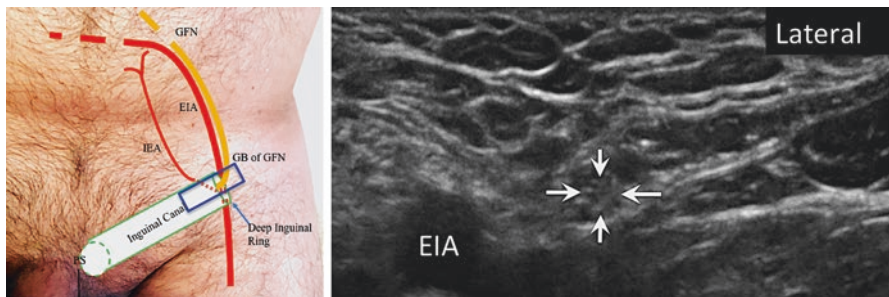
Position of ultrasound probe and the corresponding sonography revealing the genital branch of the genitofemoral nerve (arrows). EIA external iliac artery. (Reprinted with permission from Philip Peng Educational Series)
